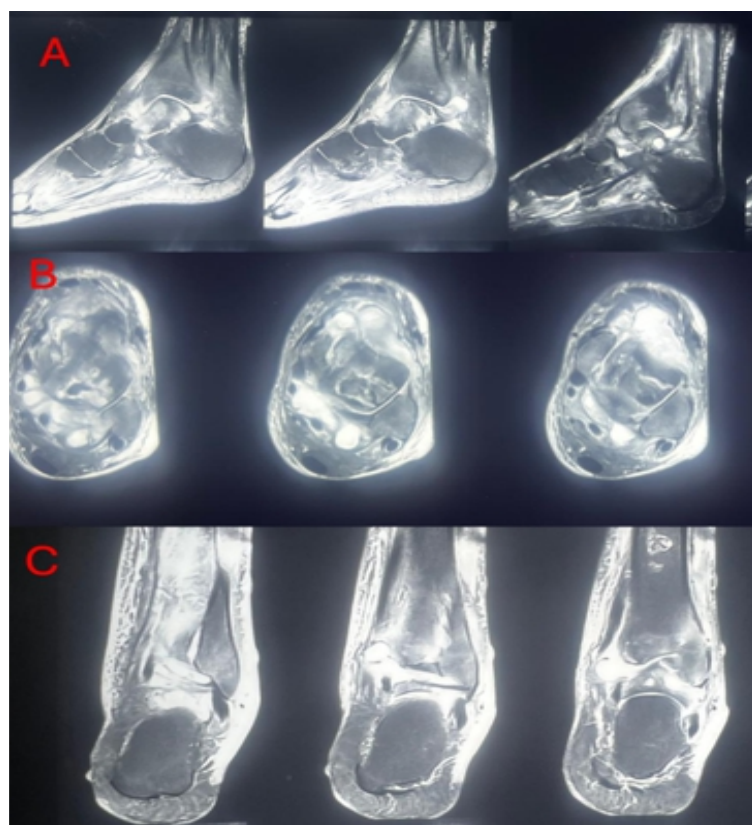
Pre-operative MRI of the left ankle – sagittal (a), axial (b), and coronal views (c). T2 and short tau inversion recovery sequences demonstrating diffuse synovial thickening, complex joint effusion, and subchondral bone marrow edema involving the tibial plafond and talar dome, consistent with septic arthritis. MRI: Magnetic resonance imaging.
